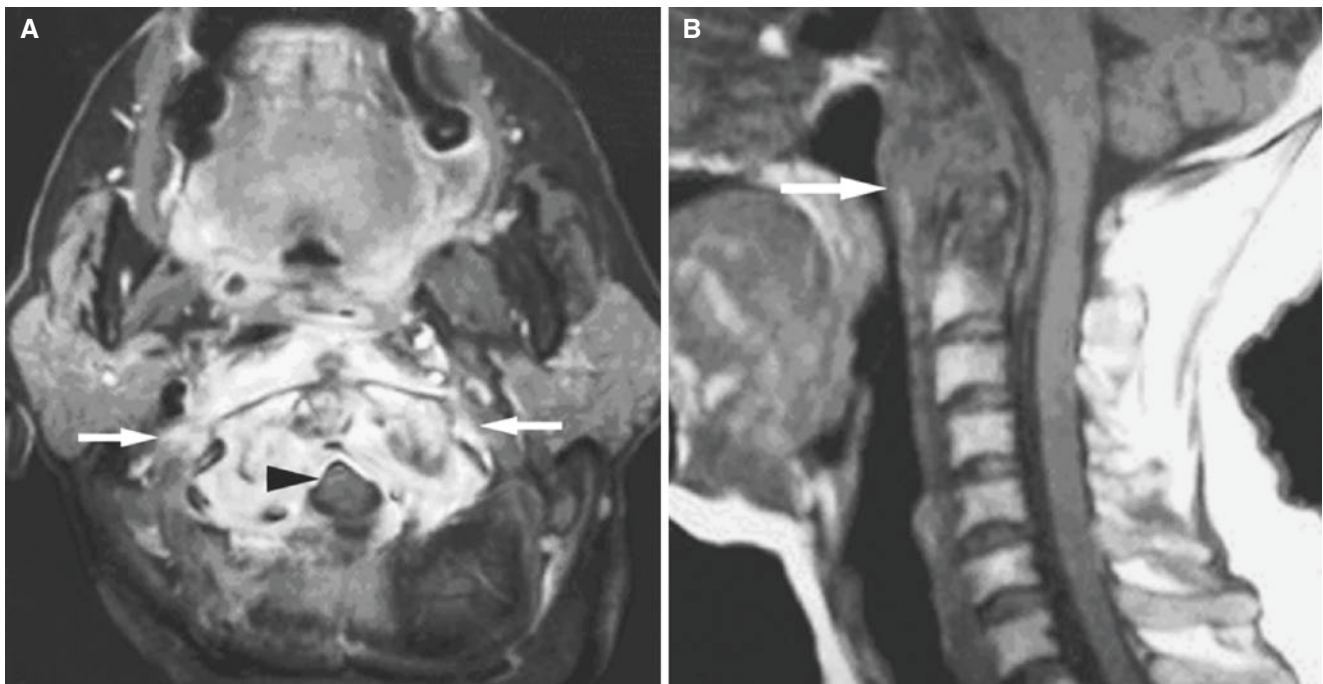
Tuberculosis at craniocervical junction; 50-year-old female presented with history of neck ache and low-grade fever for 2 months. (A) Axial T1-weighted post-Gd MRI shows destruction and erosion of atlantoaxial joint with an enhancing soft-tissue mass (arrows). A small
